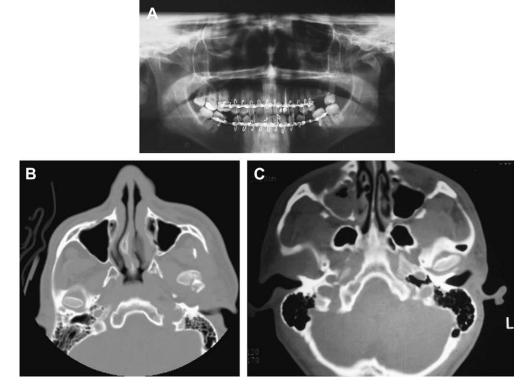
(*A*) Panoramic radiograph demonstrating the anterior displacement of the condylar segment on left side. (*B*) Axial CT demonstrating anterior displacement of the condylar head. (*C*) Axial CT scan demonstrating "empty fossa" sign due to dislocation of condyle from right glenoid fossa.
